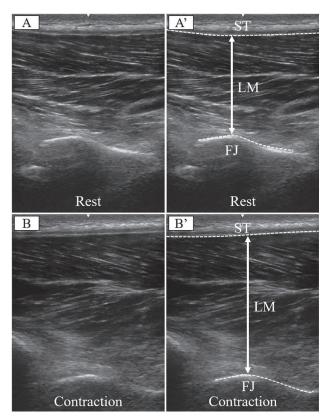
Ultrasonographic image of the lumbar multifidus muscle. Figure A is an ultrasonographic image during relaxation, and Figure B is an image during contraction. ST, subcutaneous tissue; LM, lumbar multifidus muscle; FJ, facet joint
